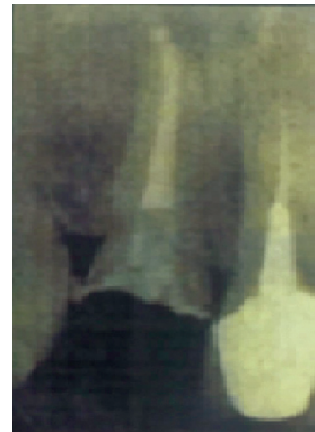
Post operative radiograph after treatment.
